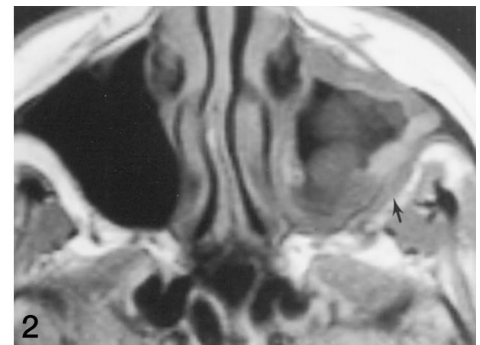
Case 2: Invasive aspergillosis. Axial T1-weighted MR image (600/15/2 [repetition time/echo time/excitations]) shows infiltration of the left posterior periantral fat plane (arrow).
